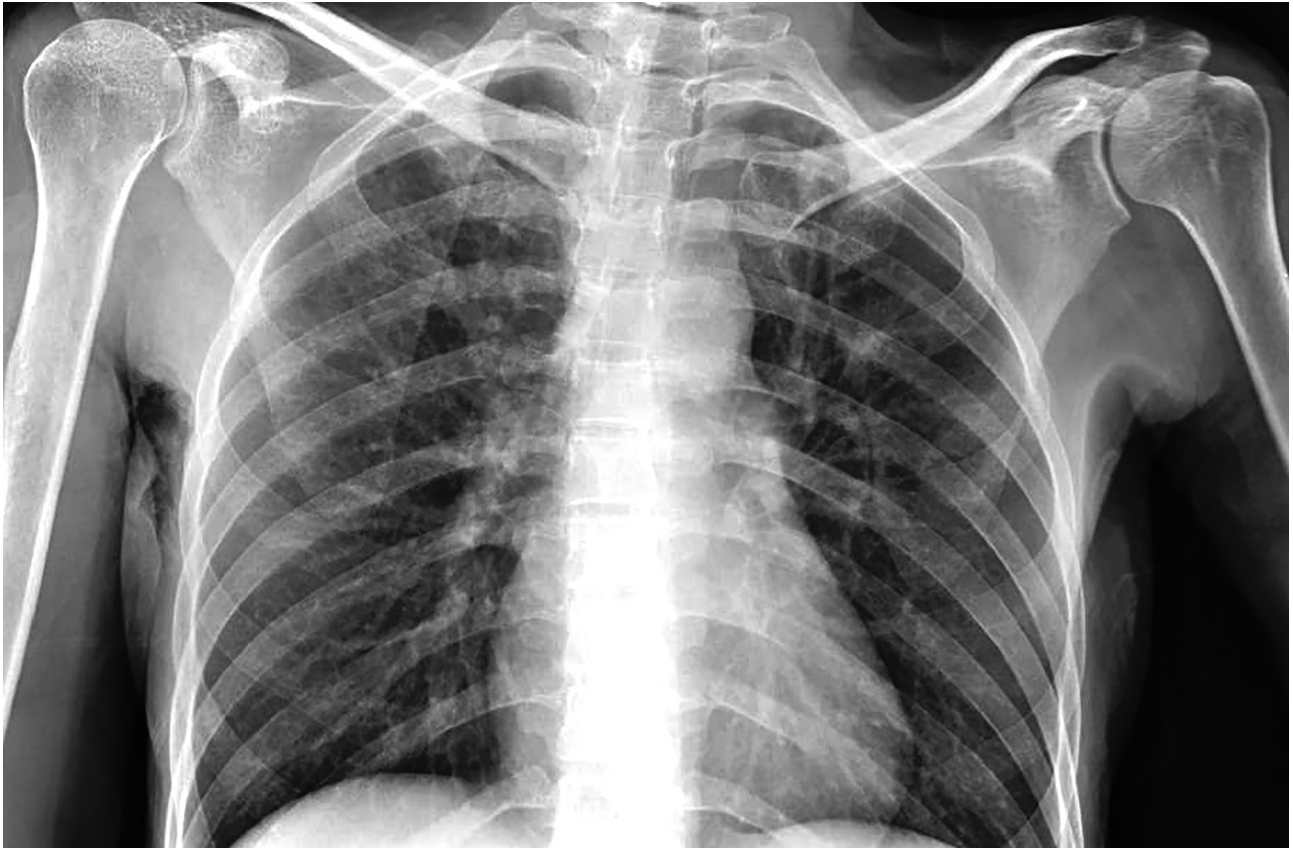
Pulmonary X-ray of the reported case on admission.
